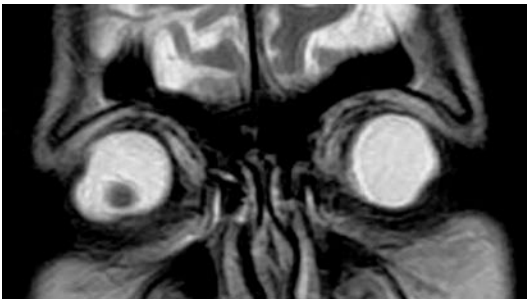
An MRI of lens luxation. The accidental discovery¹ of luxation of the right lens; there is no accompanying vitreous hemorrhage. T2 coronal image (Courtesy of A. Palkó, Szeged, Hungary)
